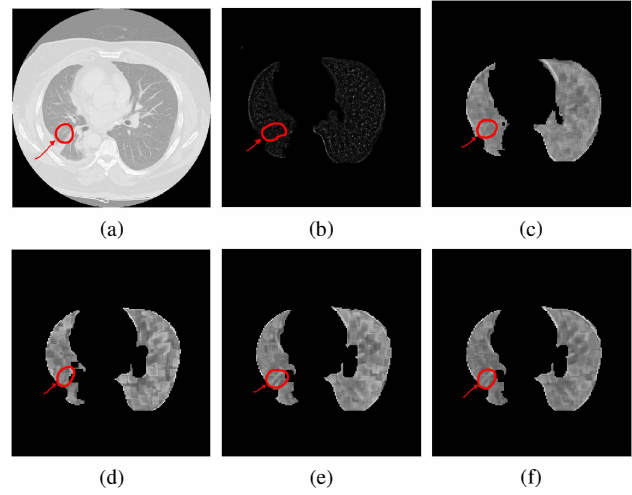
The CT image of patient which has cancer in marked area one year later. a) original CT image; b) RX-algorithm output; c) kernel RX-algorithm output with N_L neighborhood; d) kernel RX-algorithm output with N_P neighborhood; e) kernel RX-algorithm output with N_C neighborhood; f) kernel RX-algorithm output with N_M neighborhood;
